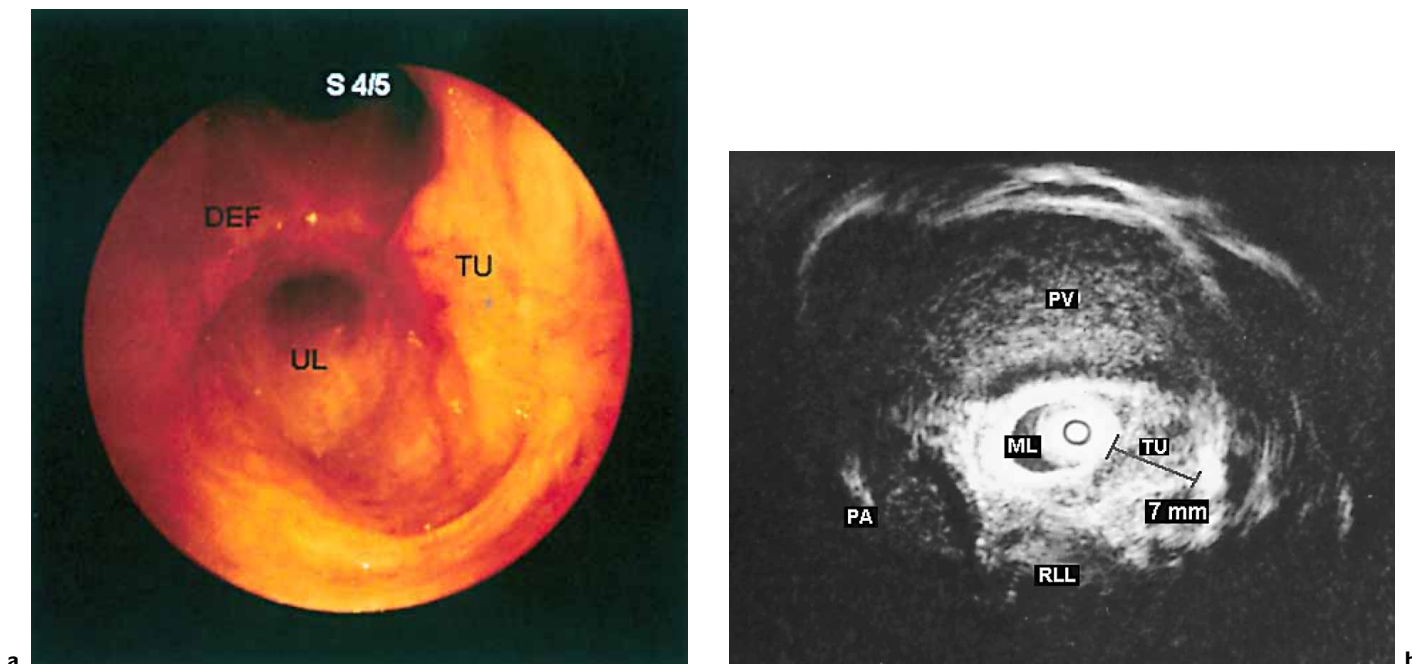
Early cancer in the middle lobe. Laterally to the middle lobe ostium, a small protrusion of the bronchial wall may be recognized which represents a small squamous cell carcinoma. The slightly bleeding defect on the carina to the middle lobe (S 4/5), ventrally to the lower lobe ostium, resulted from biopsy (DEF) (a). The tumor was neither visible on plain X-ray nor on CT scan, which is a common definition for early lung cancer. Ultrasound examination of the middle lobe bronchus (ML) demonstrates a lesion of 7 mm (TU) in diameter which is confined to the bronchial wall. Pulmonary artery (PA) and vein (PV) are intact (b). The patient was treated by lower bilobectomy. UL/RLL = Right lower lobe.
